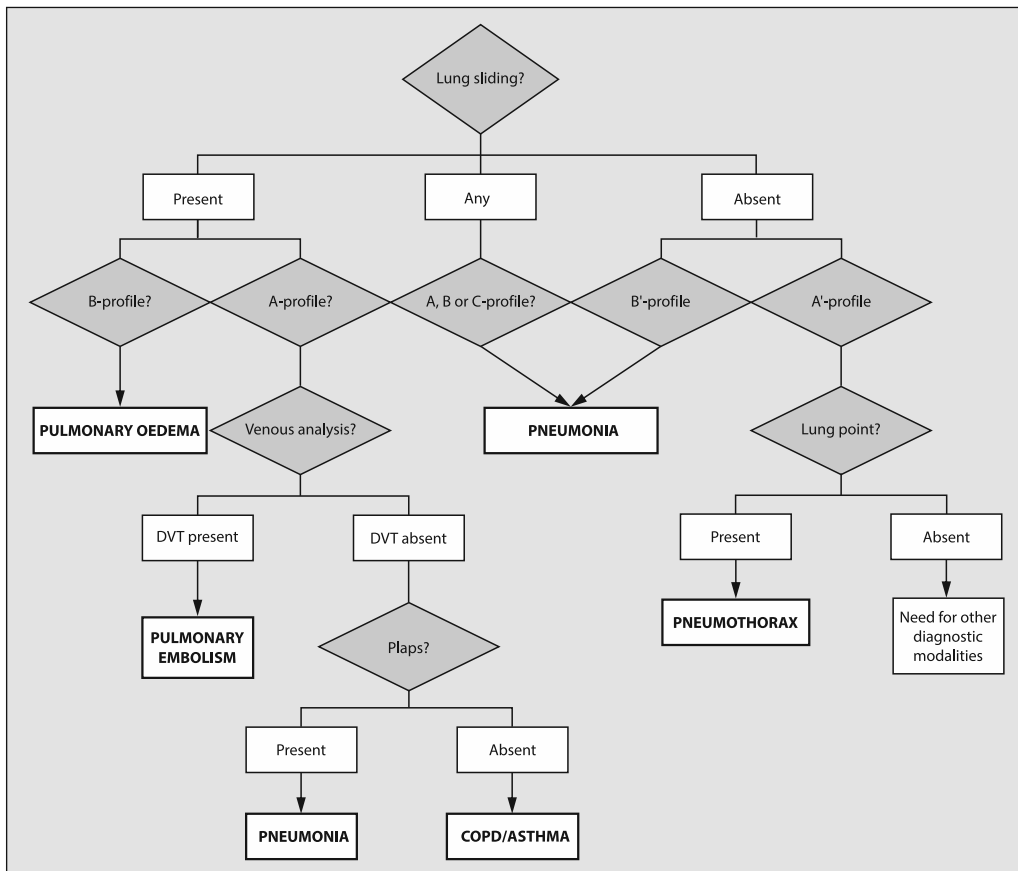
The modified BLUE protocol starting at the upper and lower BLUE points looking for lung sliding, and moving to the PLAPS point allows immediate differential diagnosis of the main causes of acute respiratory failure using lung and venous ultrasound. The decision tree should only be seen a guidance for diagnosis (with an accuracy of around 90%). Adapted from [7]. PLAPS = Postero Lateral Alveolar and/or Pleural Syndrome. COPD = chronic obstructive pulmonary disease. See text for explanation.
